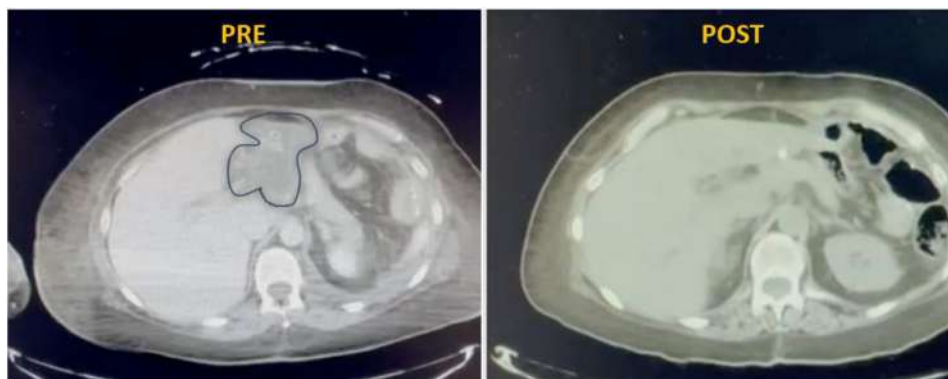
CT before and after treatment with the homemade modified endoscopic vacuum therapy with instillation device.
